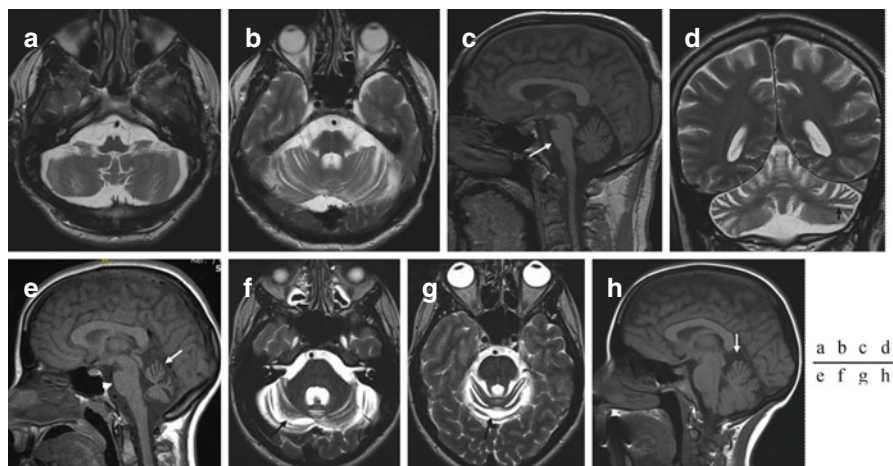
Brain imaging in SCAs. (a–c) Brain MRI in a 52-year-old man presenting a SCA2. Atrophy of the medulla, pons, and cerebellum on T2-weighted axial images (a, b). Flattening of the pons on T1-weighted sagittal image (c; see *white arrow*). Atrophy of the cerebellar cortex on coronal T2-weighted image (*black arrow*, d) in a 44-year-old man with a SCA2. Atrophy of the vermis (*white arrow*) and slight flattening of the pons (*arrowhead*) in a 23-year-old woman presenting a SCA8 (e; T1-weighted sagittal image). The atrophy of the cerebellar cortex is well identified on T2-weighted axial images in this patient (f–g; *black arrows*). Slight atrophy of the upper vermis in a patient presenting EA2 (h; sagittal T1-weighted image; *white arrow*)
